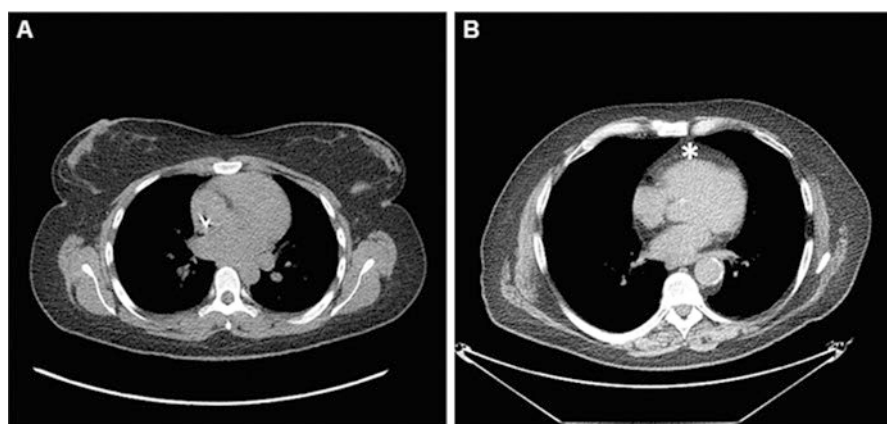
Non-contrast CT of the chest for assessment of pericardial adipose tissue in a 33-year-old woman with obesity (BMI 31 kg/m²) (a) and an age- and BMI-matched man (b). The man had higher pericardial adipose tissue area (*asterisk*) compared to the woman despite the same BMI
